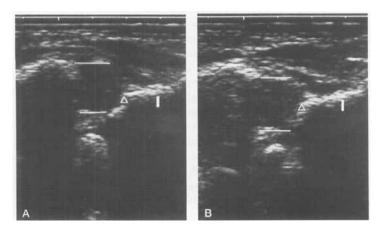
Ultrasonograms at birth of a girl with positive Ortolani test. The hip is subluxated in the neutral position (A) and reduced when the hip is flexed and abducted (B). On the images, the lower horizontal line marks the medial tangent of the femoral head; other symbols as in Figure 1.
